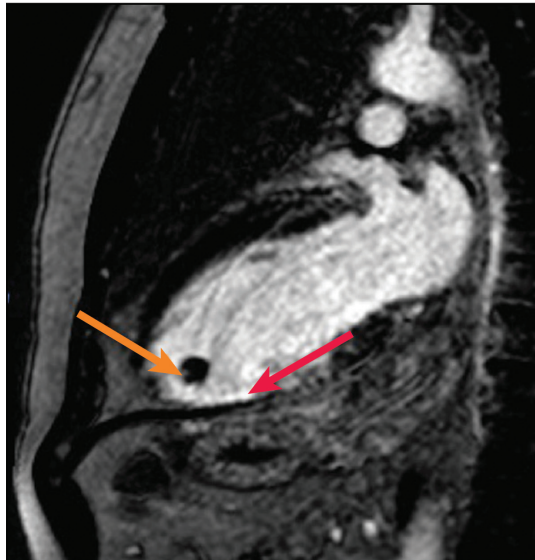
Cardiac magnetic resonance imaging with a delayed-enhancement phase-sensitive inversion recovery image, vertical long-axis view. The red arrow points to dense subendocardial delayed enhancement in the apex extending into the mid-inferior wall, consistent with scar in the distal left anterior descending artery territory. The orange arrow shows a nonenhancing mass in the apex, consistent with thrombus.
